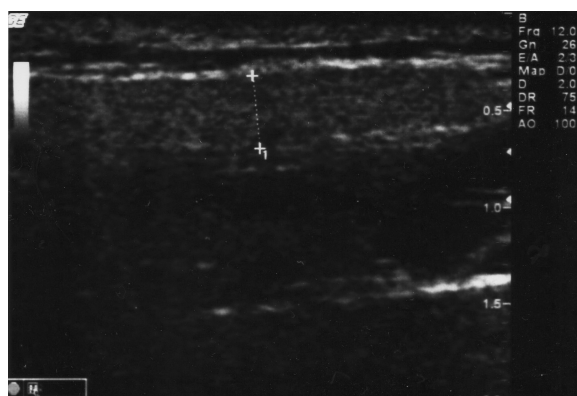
Ultrasound image shows the parotid gland as a homogenous hyperechoic structure.
